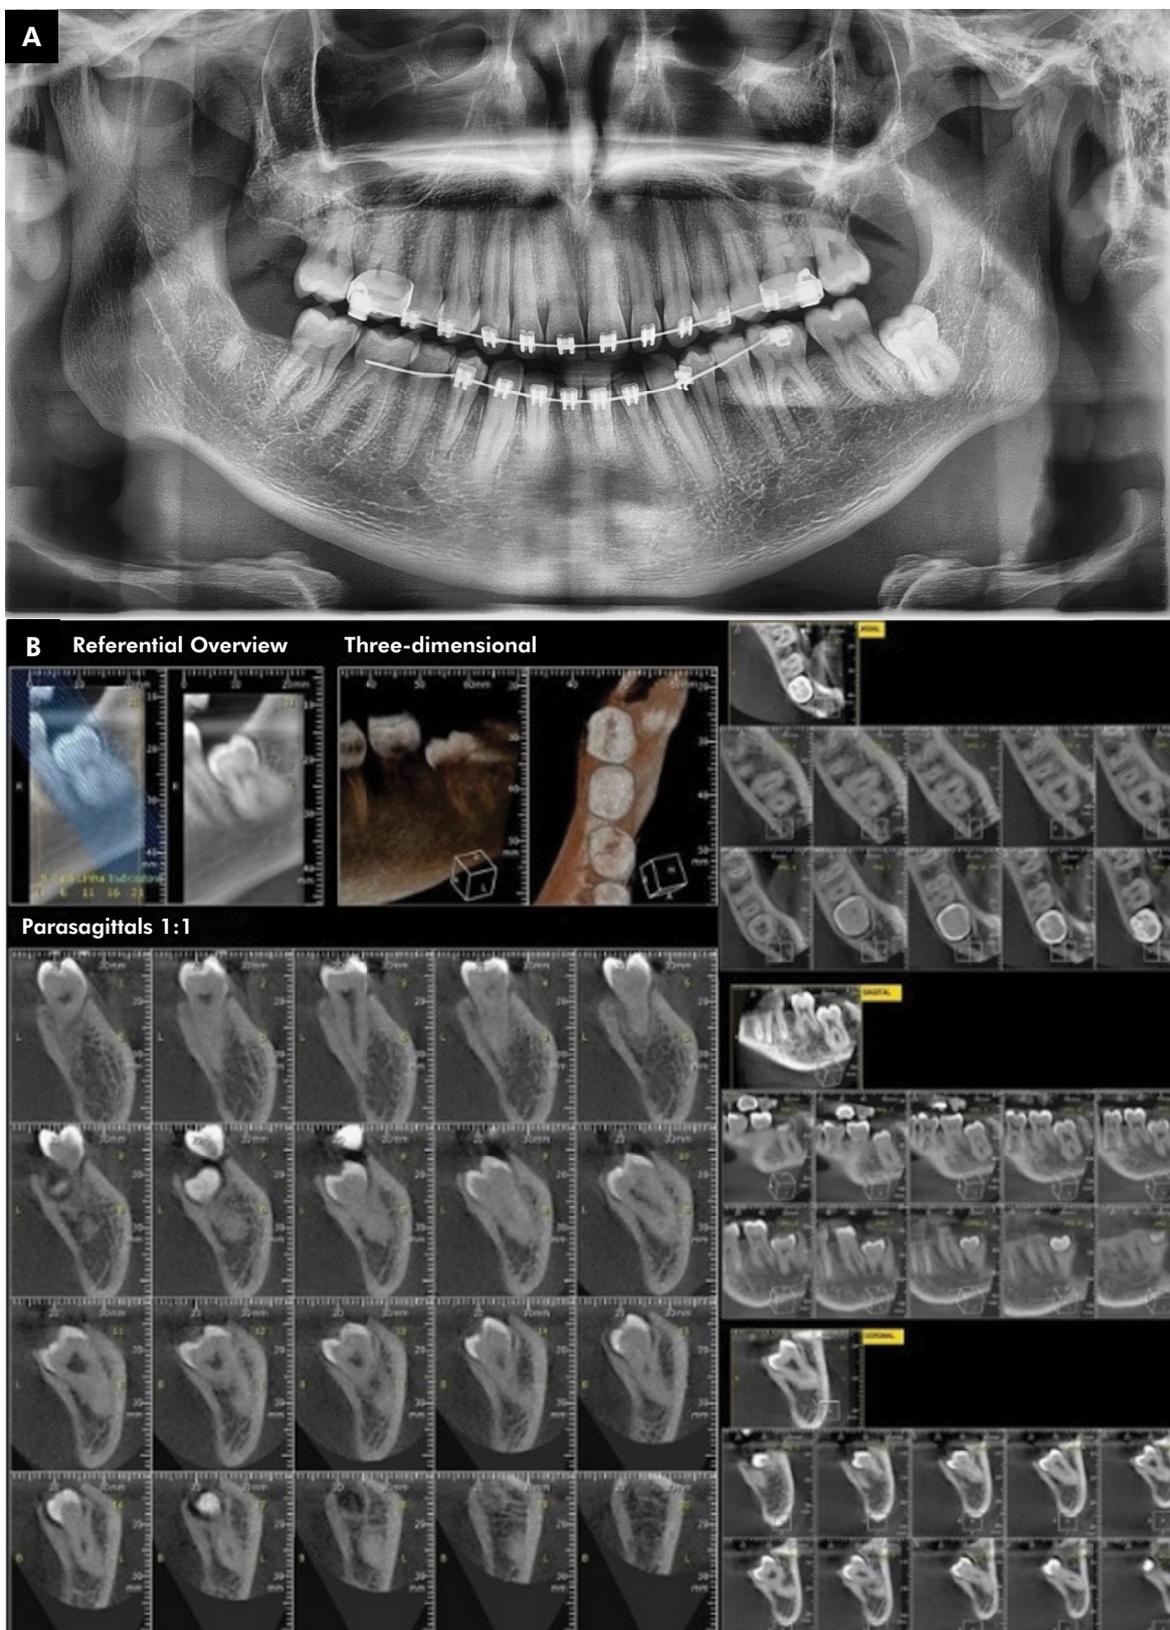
(A) panoramic radiograph from the first questionnaire and (B) multiplanar tomographic sections from the second questionnaire.
